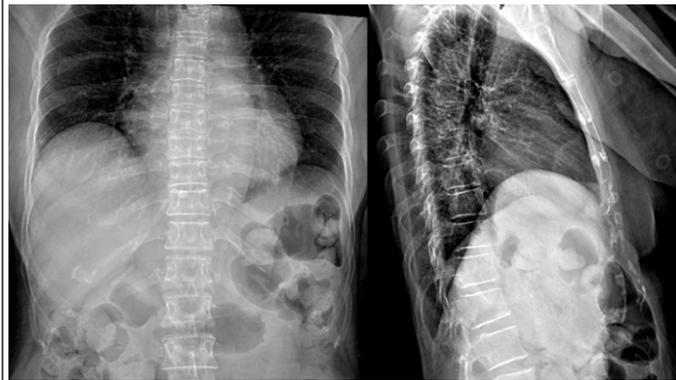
Plain X-ray of thoracolumbar spine showing rarefaction of vertebrae with degenerative changes.
